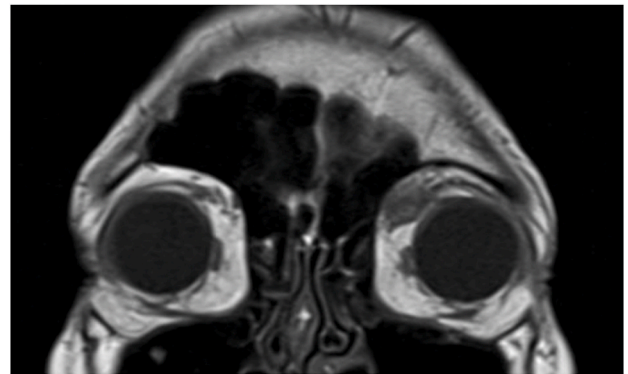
MRI at the time of the patient's initial fall 3 years prior to presentation. The MRI demonstrates an extraconal soft tissue lesion in the superiomedial quadrant of the left orbit between the superior oblique and the superior rectus that was thought to be a hematoma. The lesion was isointense to T1 and hypointense to T2.
